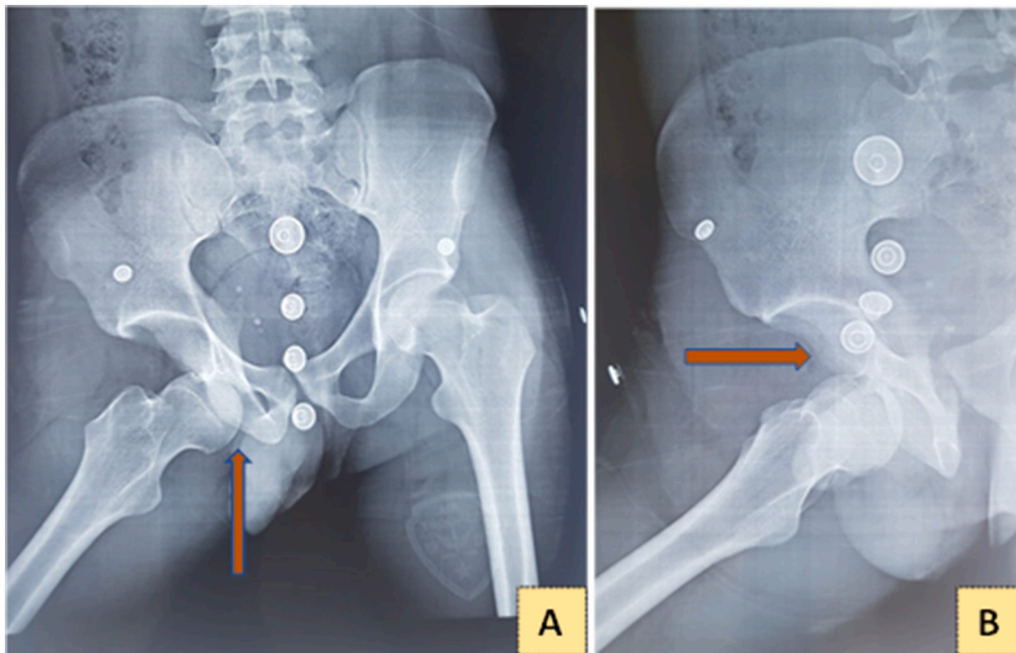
Case 2: A and B. X-rays of the pelvis AP and 3/4 alar of the hip showing obturator dislocation with vacuity of the acetabulum.
